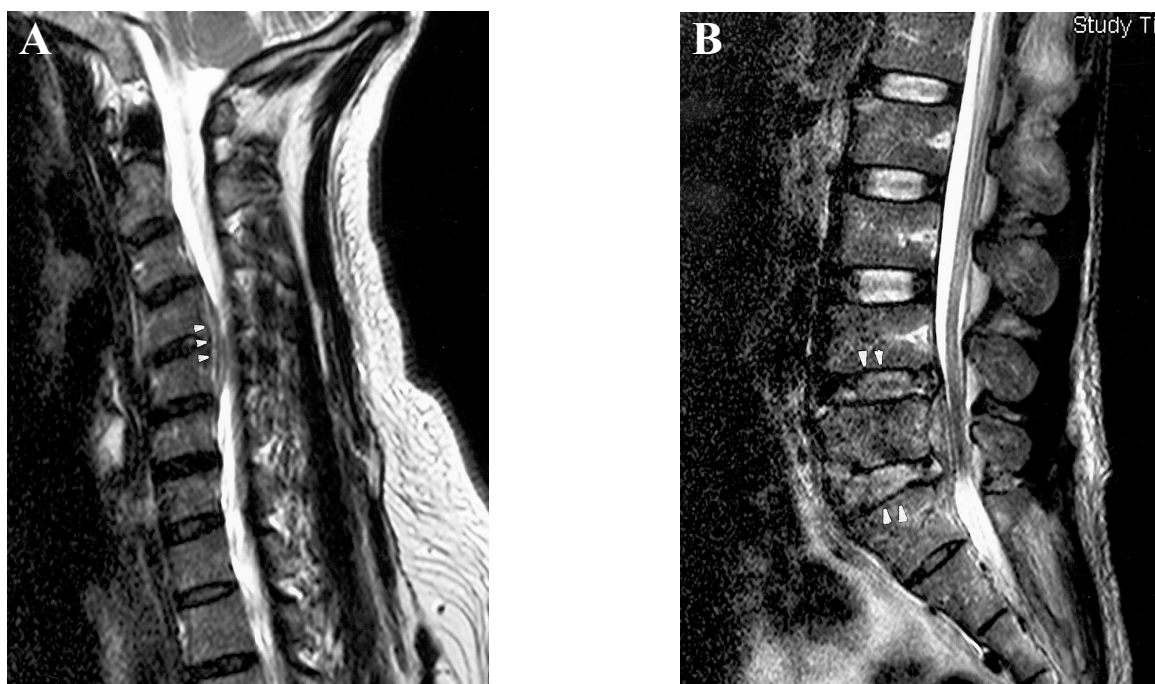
T2-weighted, sagittal MRI scans enable a precise demonstration of the size and extent of a spinal epidural abscess (SEA): (A) A mass anterior to and displacing the spinal cord from C4 to C5; (B) Irregularity and destruction of the vertebral body end plates of inferior L4 to superior S1.
